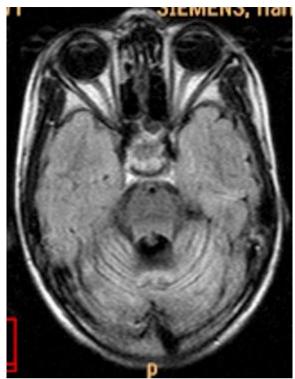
(a): T2W and FLAIR axial images showing atrophy of bilateral cerebellar hemispheres and vermis.
